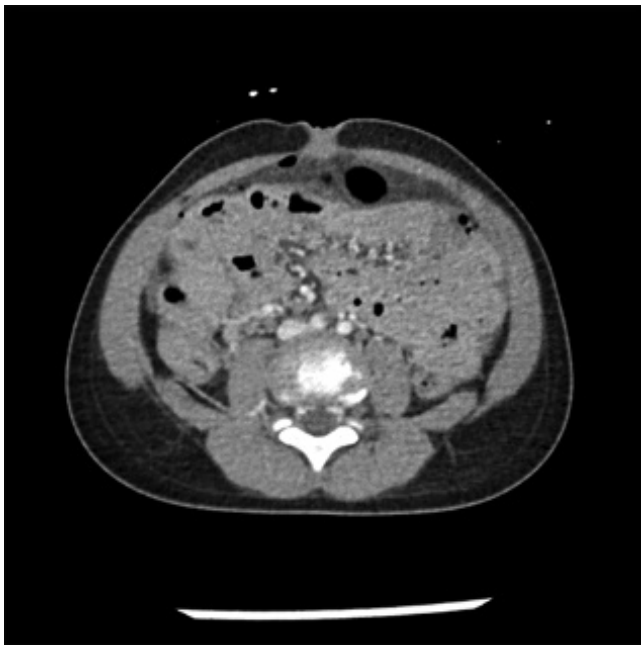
CT demonstrating free intraperitoneal air, free fluid, and thickened bowel loops. This child had a small bowel perforation associated with a seat belt sign.
